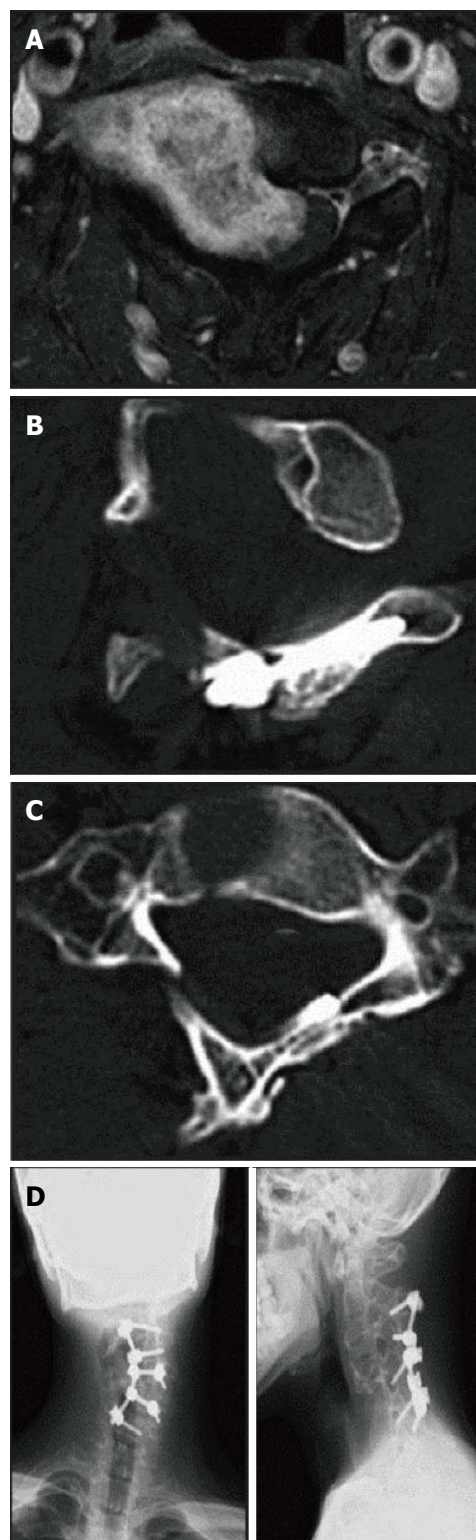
Case 1. A: A magnetic resonance imaging scan image showing a dumbbell-shaped schwannoma at the C3 level; B, C: Computed tomography images showing an appropriately inserted C4 laminar screw (B) and a C6 laminar screw with minimal canal invasion (C); D: A roentgenogram showing solid bone fusion after C2-6 laminar screw fixation.
